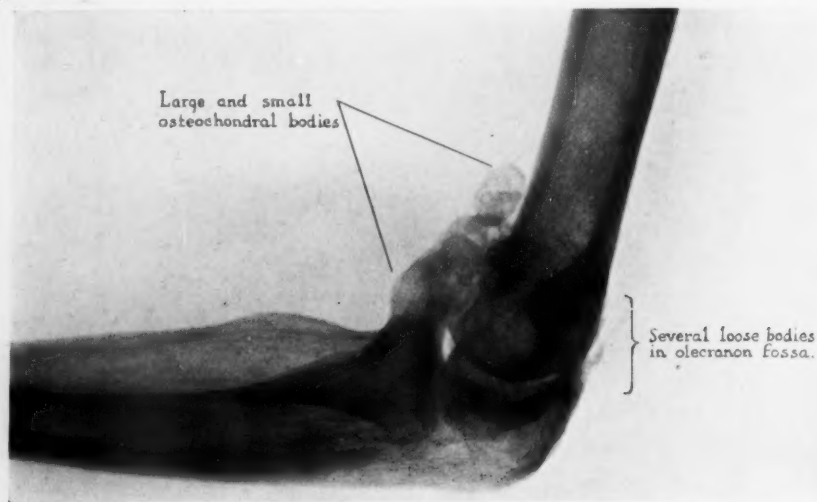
(Case II.) Lateral roentgenogram of right elbow. Left elbow shows similar lesion. There are seen numerous bodies of varying sizes in both the anterior and posterior compartments of the elbow. The articular cartilages are clear, and there is no roughening of bone at the articular junctions, so that there is no sign of any arthritis.
